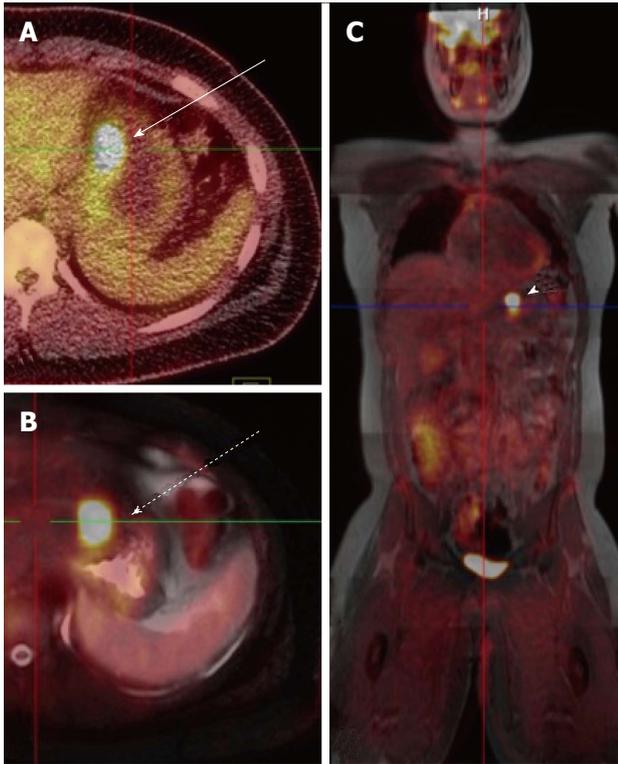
14-year-old male with gastrointestinal stromal tumor. Axial fused PET-CT image (A) shows intense uptake along the lesser curvature of the stomach (white arrow). Axial fused PET-MRI image (B) (T2-weighted HASTE sequence) shows similar intense uptake along the lesser curvature (dashed arrow). Coronal whole body fused PET-MRI image (C) (T1 VIBE sequence) shows intense uptake in the same region (arrowhead). PET-MRI: Positron emission tomography-magnetic resonance imaging; CT: Computed tomography.
